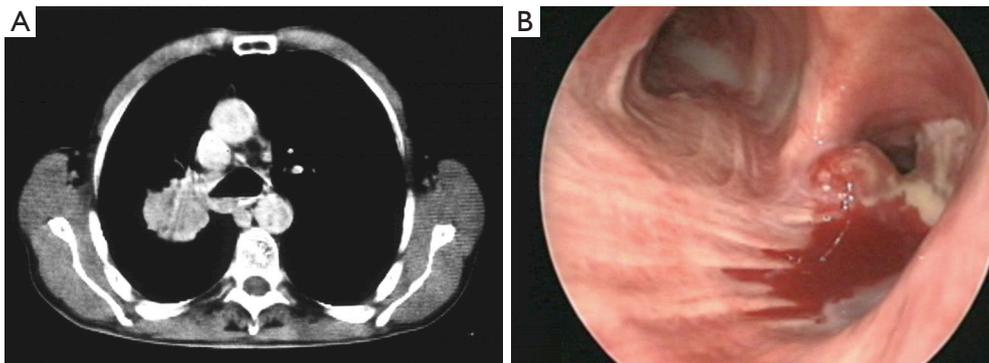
A Chest computed tomography scan showing a tracheal tumor involving the carina and the right main bronchus. B. Bronchoscopic view of the tumor involving the carina and the proximal part of the right main bronchus.
